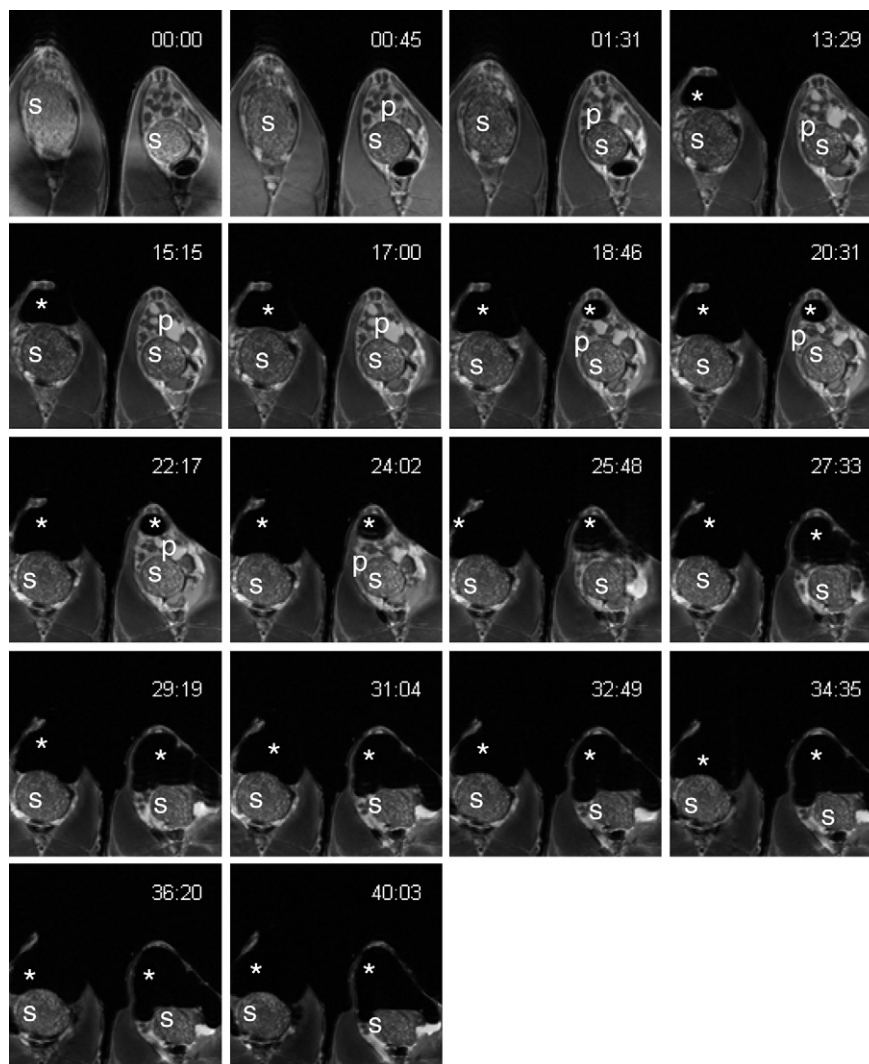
Time series of the MRI study of the first slice (head side). The herring to the left had visible signs of belly bursting before freezing onboard, while the herring to the right was frozen undamaged. The time elapsed from the beginning of the MRI examination is indicated in each image. Labelled in the figure are: the stomach (s), pyloric caeca (p) wrapped around the stomach, and the hollow space formed as during belly bursting (*).
